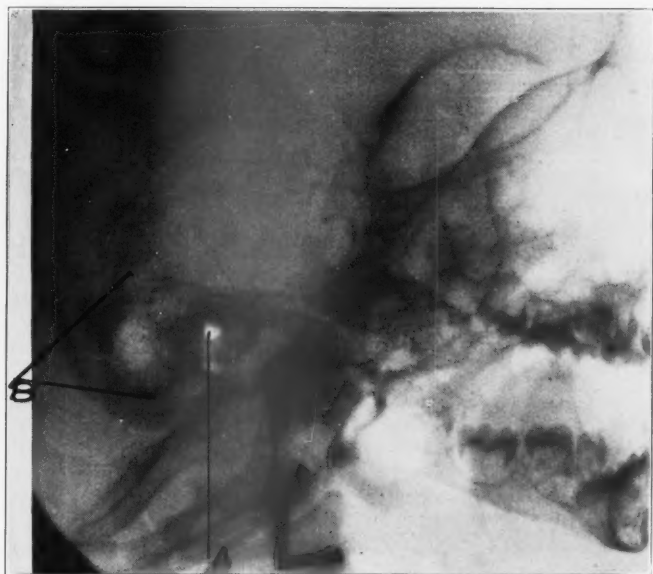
Roentgenogram of mastoid space in case reported, 8 months of age. This cavity contained air and was lined with a moist gray necrotic bony ball. The mucosa was destroyed. Infecting organism, hemolytic staphylococcus aureus. A, outline of mastoid space, showing unusual transparency through the cavity with increased bone density surrounding.
